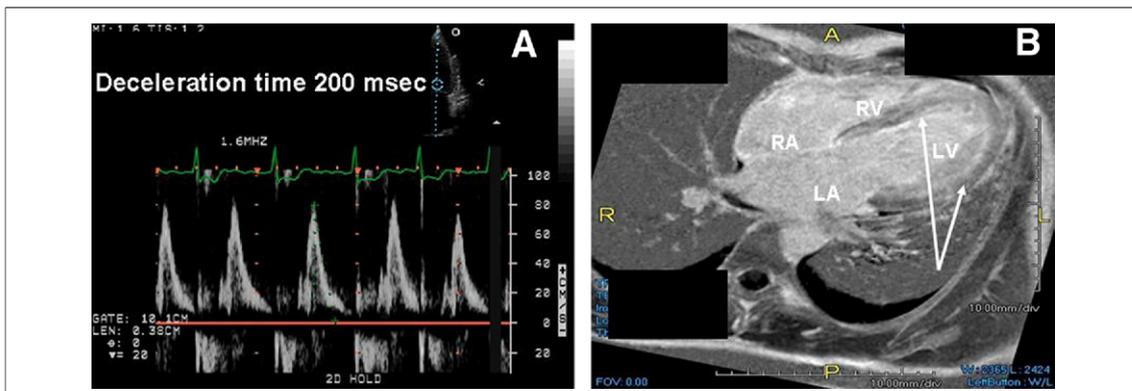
Positive Echocardiography and CMR in a Patient With CA
